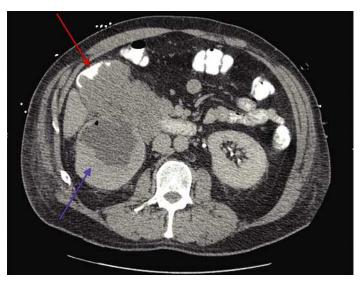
CT scan demonstrating a 10 cm, right renal mass (blue arrow) invading into the duodenum (red arrow). This patient had a predominantly sarcomatoid transformed clear cell tumor. After cytoreductive nephrectomy, rapid liver progression and carcinomatosis ensued and the patient was passed away prior to the initiation of systemic therapy. (Image provided by David Finley, MD, Kaiser Sunset, Los Angeles, California).
